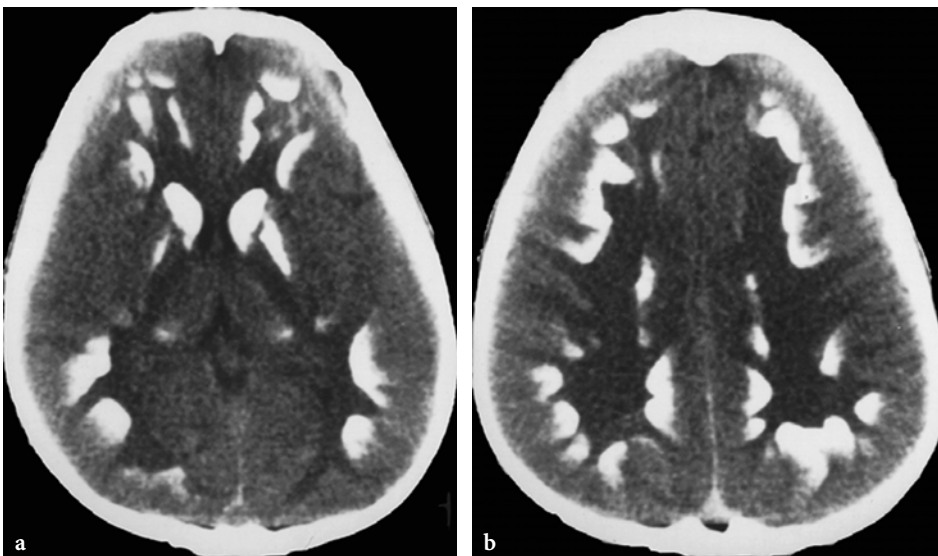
CT findings in carbonic anhydrase II deficiency. a, b Nonenhanced axial CT images. Dense calcifications within the cerebral hemispheres involving the subcortical white matter and the deep gray matter structures
